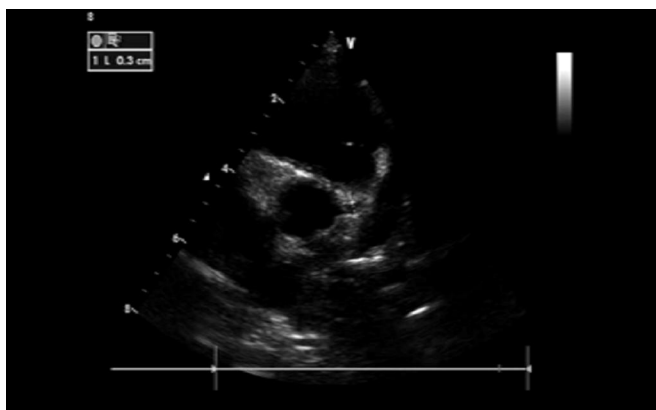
Echocardiography Showing Coronary Artery Dilatation With Aneurysm
